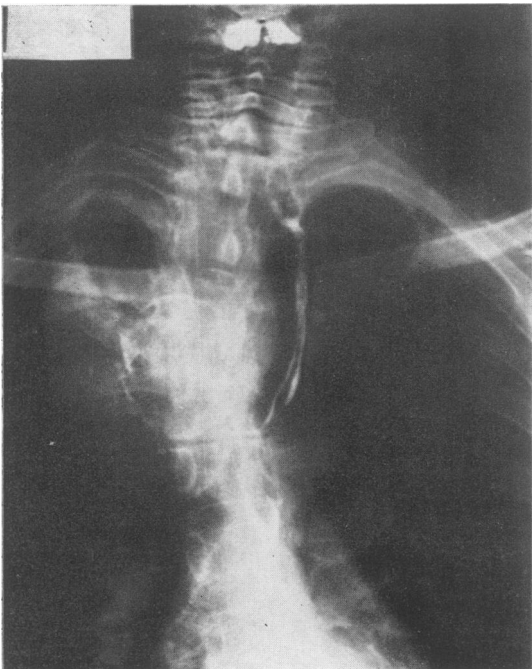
X-ray after barium swallow.
